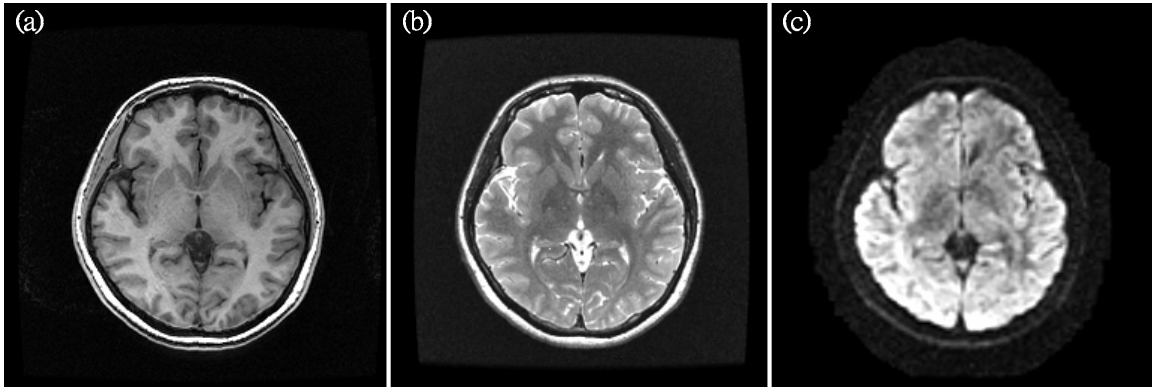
MR images acquired using different pulse sequences. (a) T1-weighted MR image. (b) T2-weighted MR image. (c) Diffusion tensor image.
